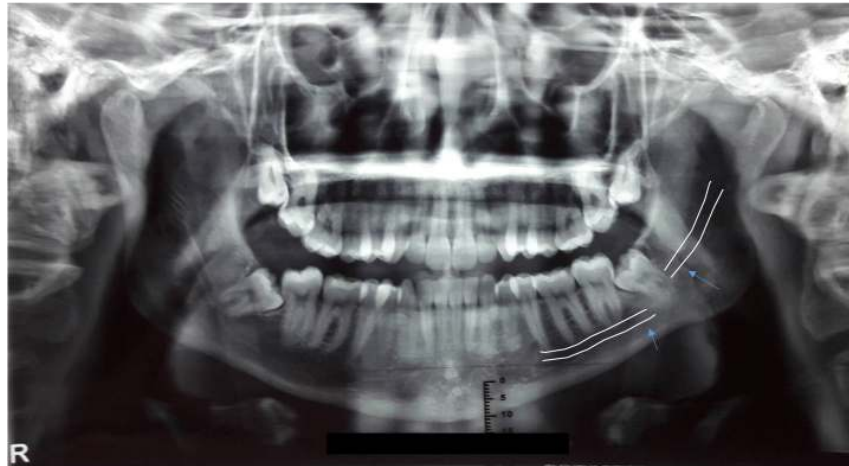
Panoramic radiograph showing the deviation of the mandibular canal path (represented by the white lines) and the disappearance of its image near the apex of the left lower third molar (pointed by the arrows)
